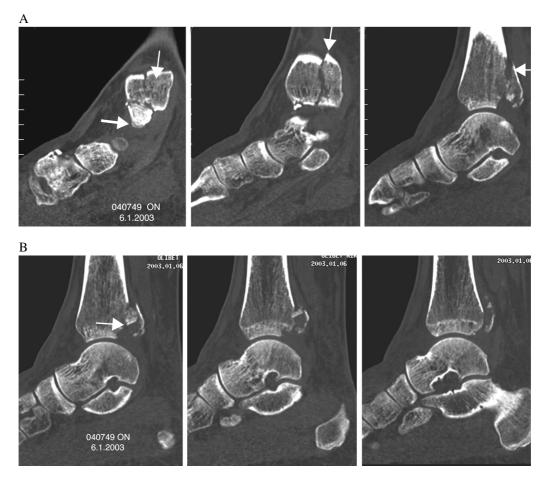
CT of the ankle of a patient (Table 1: no. 10). A, Malleolus and medial border of the plafond. B, Medial border and middle section of the ankle. Note the coronal fracture of the medial malleolus (Figure 5,A arrows). This patient had an additional fracture of the tip of the anterior colliculus (Figure 5,A left image, open arrow). Note the shortness of the remaining (anterior) portion of the tibial plafond (images 5,A, right and 5,B, left). At the posteromedial border a large osteochondral fragment is proximally displaced (Figure 5,B, left, arrow).
